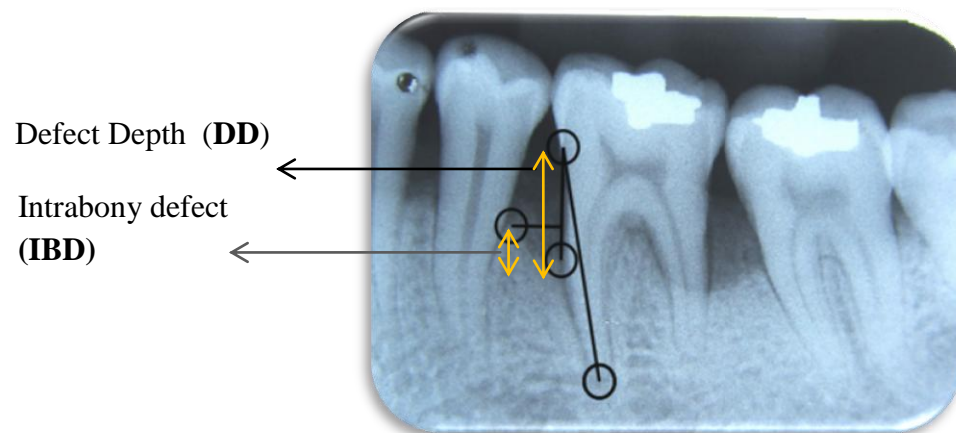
(b) : Measurement of radiographic parameters
